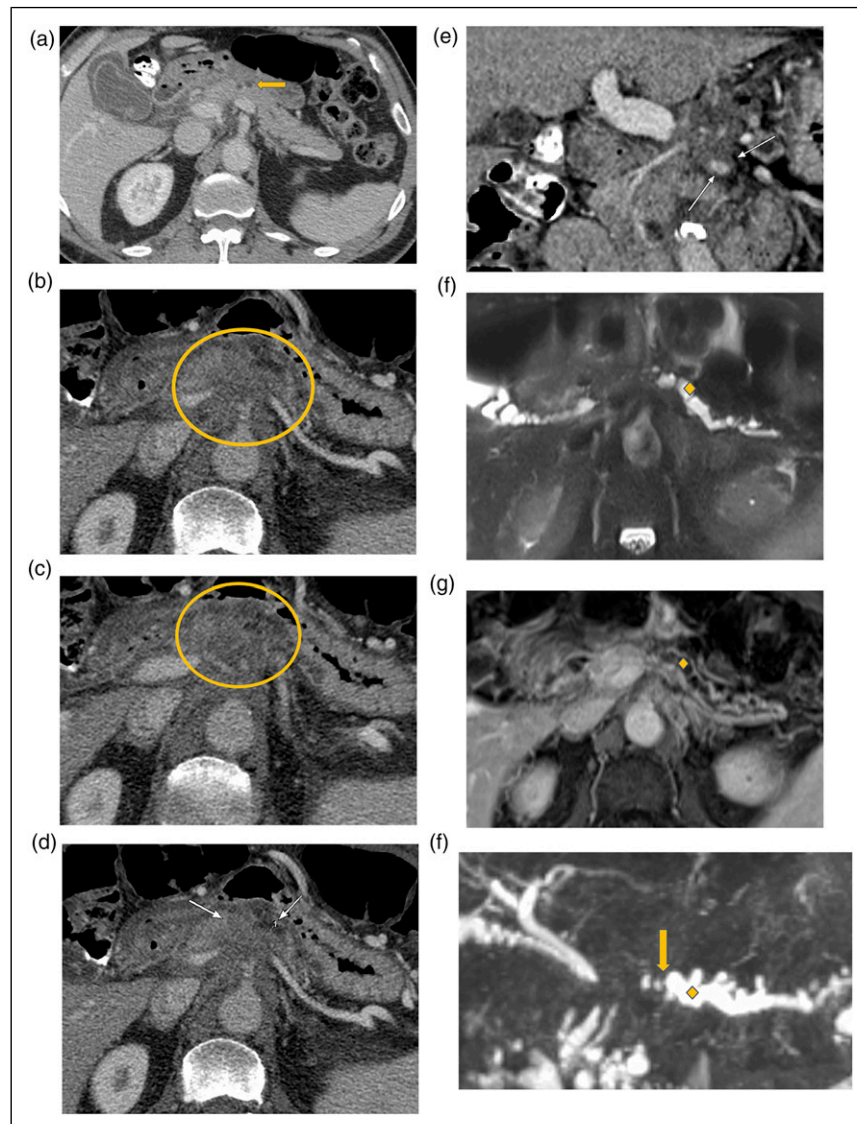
Seventy-two-year-old male. Initial PV phase CT in October 2016 (A) was performed for abdominal pain and elevated liver enzymes demonstrated circumferential gallbladder wall edema, no cirrhosis, and a hypodense pancreatic lesion (yellow arrow) without evidence of pancreatitis, for which imaging follow-up was recommended. Patient presented with pancreatitis and weight loss in May 2018 and found to have pancreatic cancer. (B-E) Axial and coronal PV phase images demonstrate a hypoenhancing pancreatic neck/body mass (yellow circle) with vascular encasement involving the splenic vein, portosplenic confluence, and superior mesenteric vein (SMV) (white arrows). (F-H) Axial T2, axial T1 post-gadolinium, and MRCP radial images demonstrate distal pancreatic ductal dilatation (yellow diamond) with upstream abrupt cut-off (yellow arrow) at the level of the mass.
